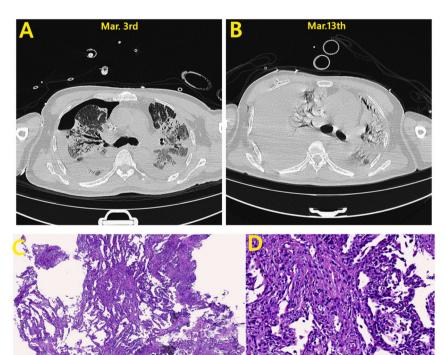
One of the three deaths in the critically ill patients was a 71-year-old man, whose CT scan showed rapid progression in his lung(A, B). Two weeks after admission, bronchoscopy was performed when his CT scan showed almost complete pulmonary consolidation. Pathological manifestations included obvious inflammatory exudation, hyperplasia of alveolar epithelium, thickening of interstitial space and local formation of granulomatous nodule. And proliferation of fibroblasts and lymphocytes were found in the nodule(C, HEX 4 & D, HEX 20).
